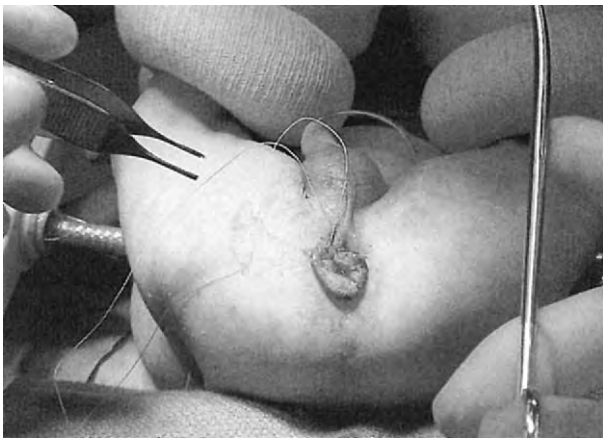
The pull-through is completed, and the anorectoplasty is being performed. (From Sydorak RM, Albanese CT: Laparoscopic repair of high imperforate anus. *Semin Pediatr Surg* 11: 217-225, 2002.)
